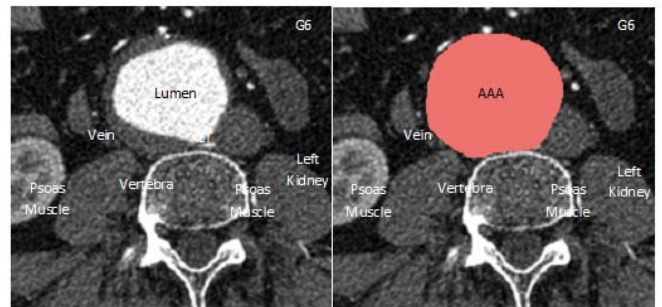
Pre- and post-segmentation of a representative CT image from G6 showing AAA interaction with the vertebral column.
